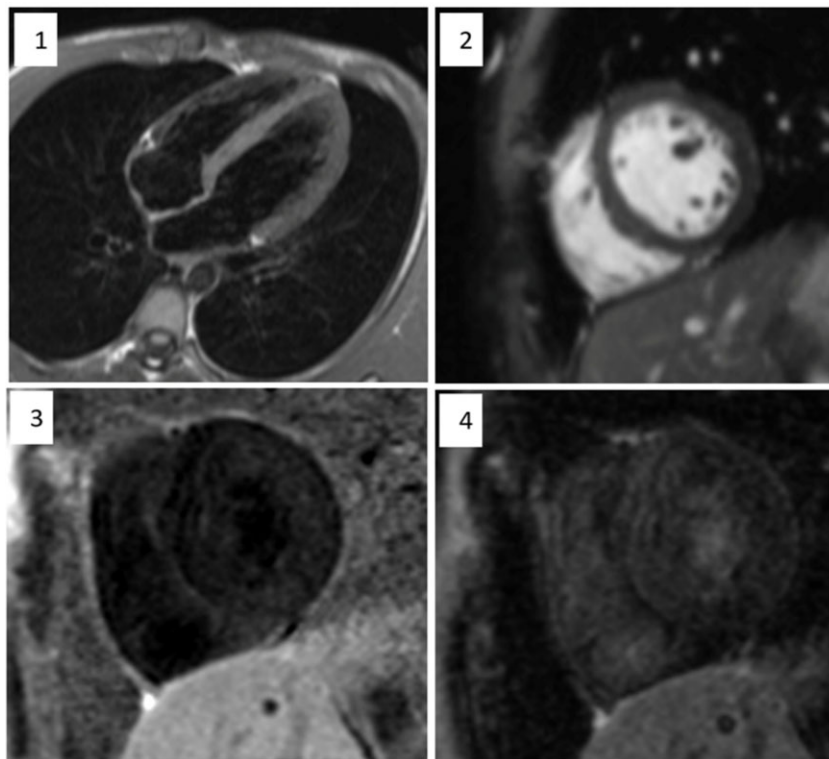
A cardiac MRI was performed, including a four-chamber view using the T2-weighted inversion recovery (TIRM) sequence (1) and short-axis imaging with the true fast imaging with steady precession (True FISP) technique (2). The results revealed no evidence of pericardial thickening. Additionally, post-administration of gadolinium, the short-axis imaging (3 and 4) exhibited no delayed enhancement in the myocardial wall, indicating a normal myocardial perfusion.
